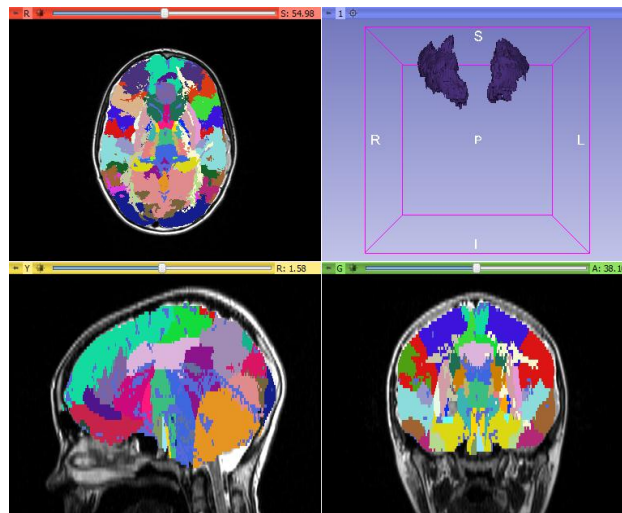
Segmentation of epileptic brain MR image
